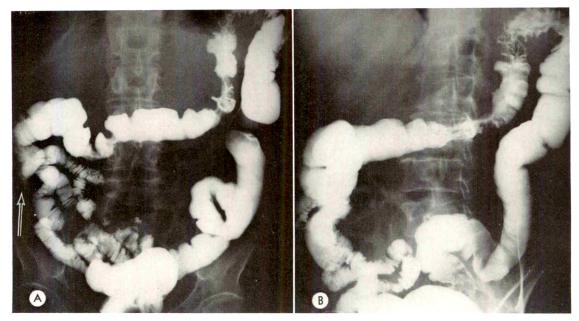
A 68 year old man complained of right-sided abdominal pain of 3 months' duration, accompanied by a 15 pound weight loss. The patient underwent exploratory surgery and partial colon resection, and died postoperatively. (A and B) Frontal and oblique roentgenograms reveal contraction and shortening of the cecum (arrow) and ascending colon. There is a lengthy skip area of involvement in the transverse colon (including the splenic flexure) with narrowing and irregularity. (Courtesy of George J. Meyer, M.D., Fort Lauderdale, Florida.)
